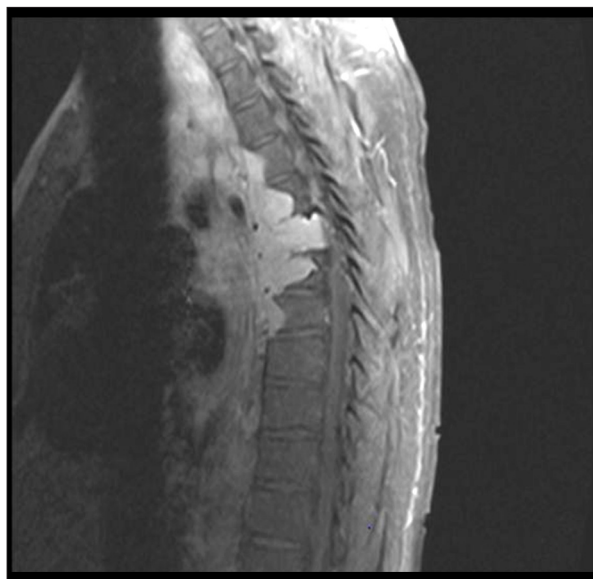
Magnetic resonance imaging of the thoracic spine showed a 10×7×4 cm lesion in the paravertebral and prevertebral soft tissue extending from T4 to T8.
